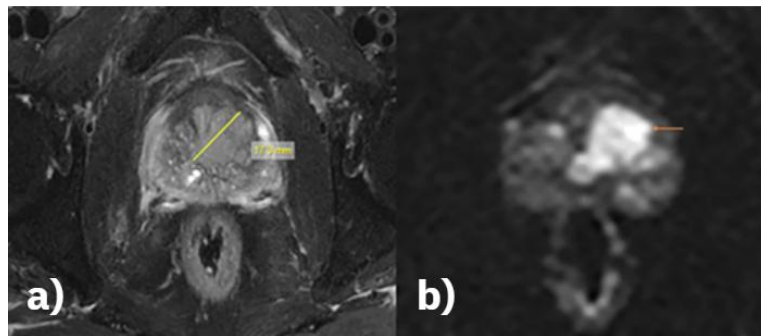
A patient diagnosed with prostatic acinar adenocarcinoma: (a) Prostate Axial T2: fat suppression sequence shows a lesion with defined boundaries. (b) Prostate DWI at a b-value of 1500 s/mm^2 : enhances the lesion's visibility compared to T2, demonstrating reduced signal-to-noise ratio (SNR) but improved CNR, enhancing cancer visibility for improved detection and characterization in prostate MRI. (from [121])
